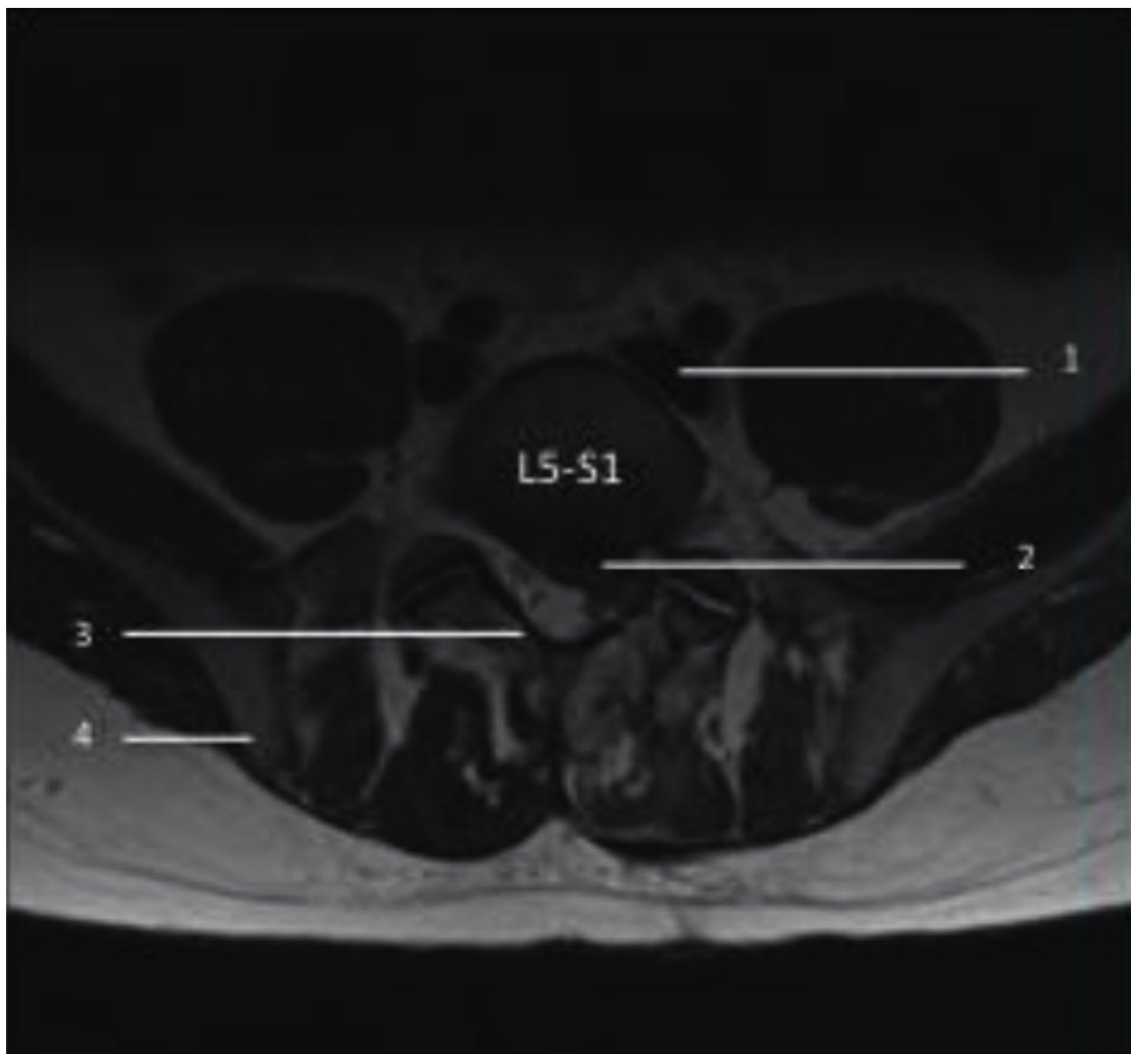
Magnetic resonance imaging axial cut at L5–S1. 1, left common iliac vein; 2, left paracentral herniated nucleus pulposus; 3, left L5 lamina; 4, ilium.
